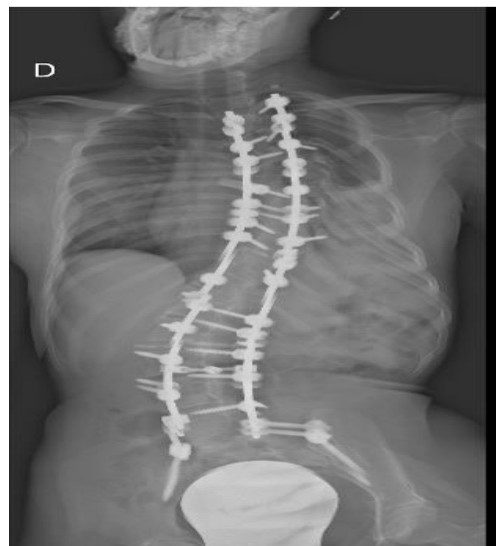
Thoraco-Abdominal Radiograph: Opacification of Lower Left Hemithorax.
